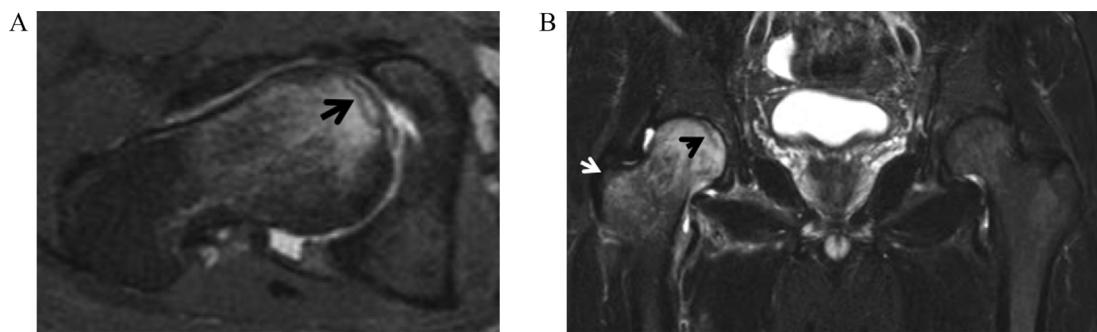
MR images of two patients with subchondral fractures. (A) A 26-year-old male. The oblique axial fat suppressed PD-w MR image shows the low signal intensity subchondral line representing the microtrabecular fracture (arrow), surrounded by moderate bone marrow edema. (B) A 46-year-old male. The coronal STIR image shows the subchondral fracture (black arrow) and the extension of bone marrow edema to the greater trochanter (white arrow).
